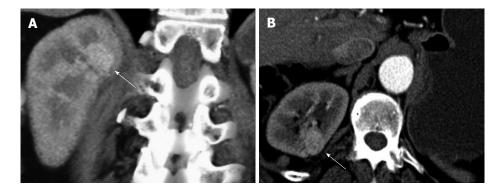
A 72-year-old female status post left nephrectomy who developed a new mass in the contralateral kidney. Note the subtle lesion in the upper pole (arrow), on coronal volume rendering (A) and axial arterial phase CT (B). CT: Computerized tomography.
